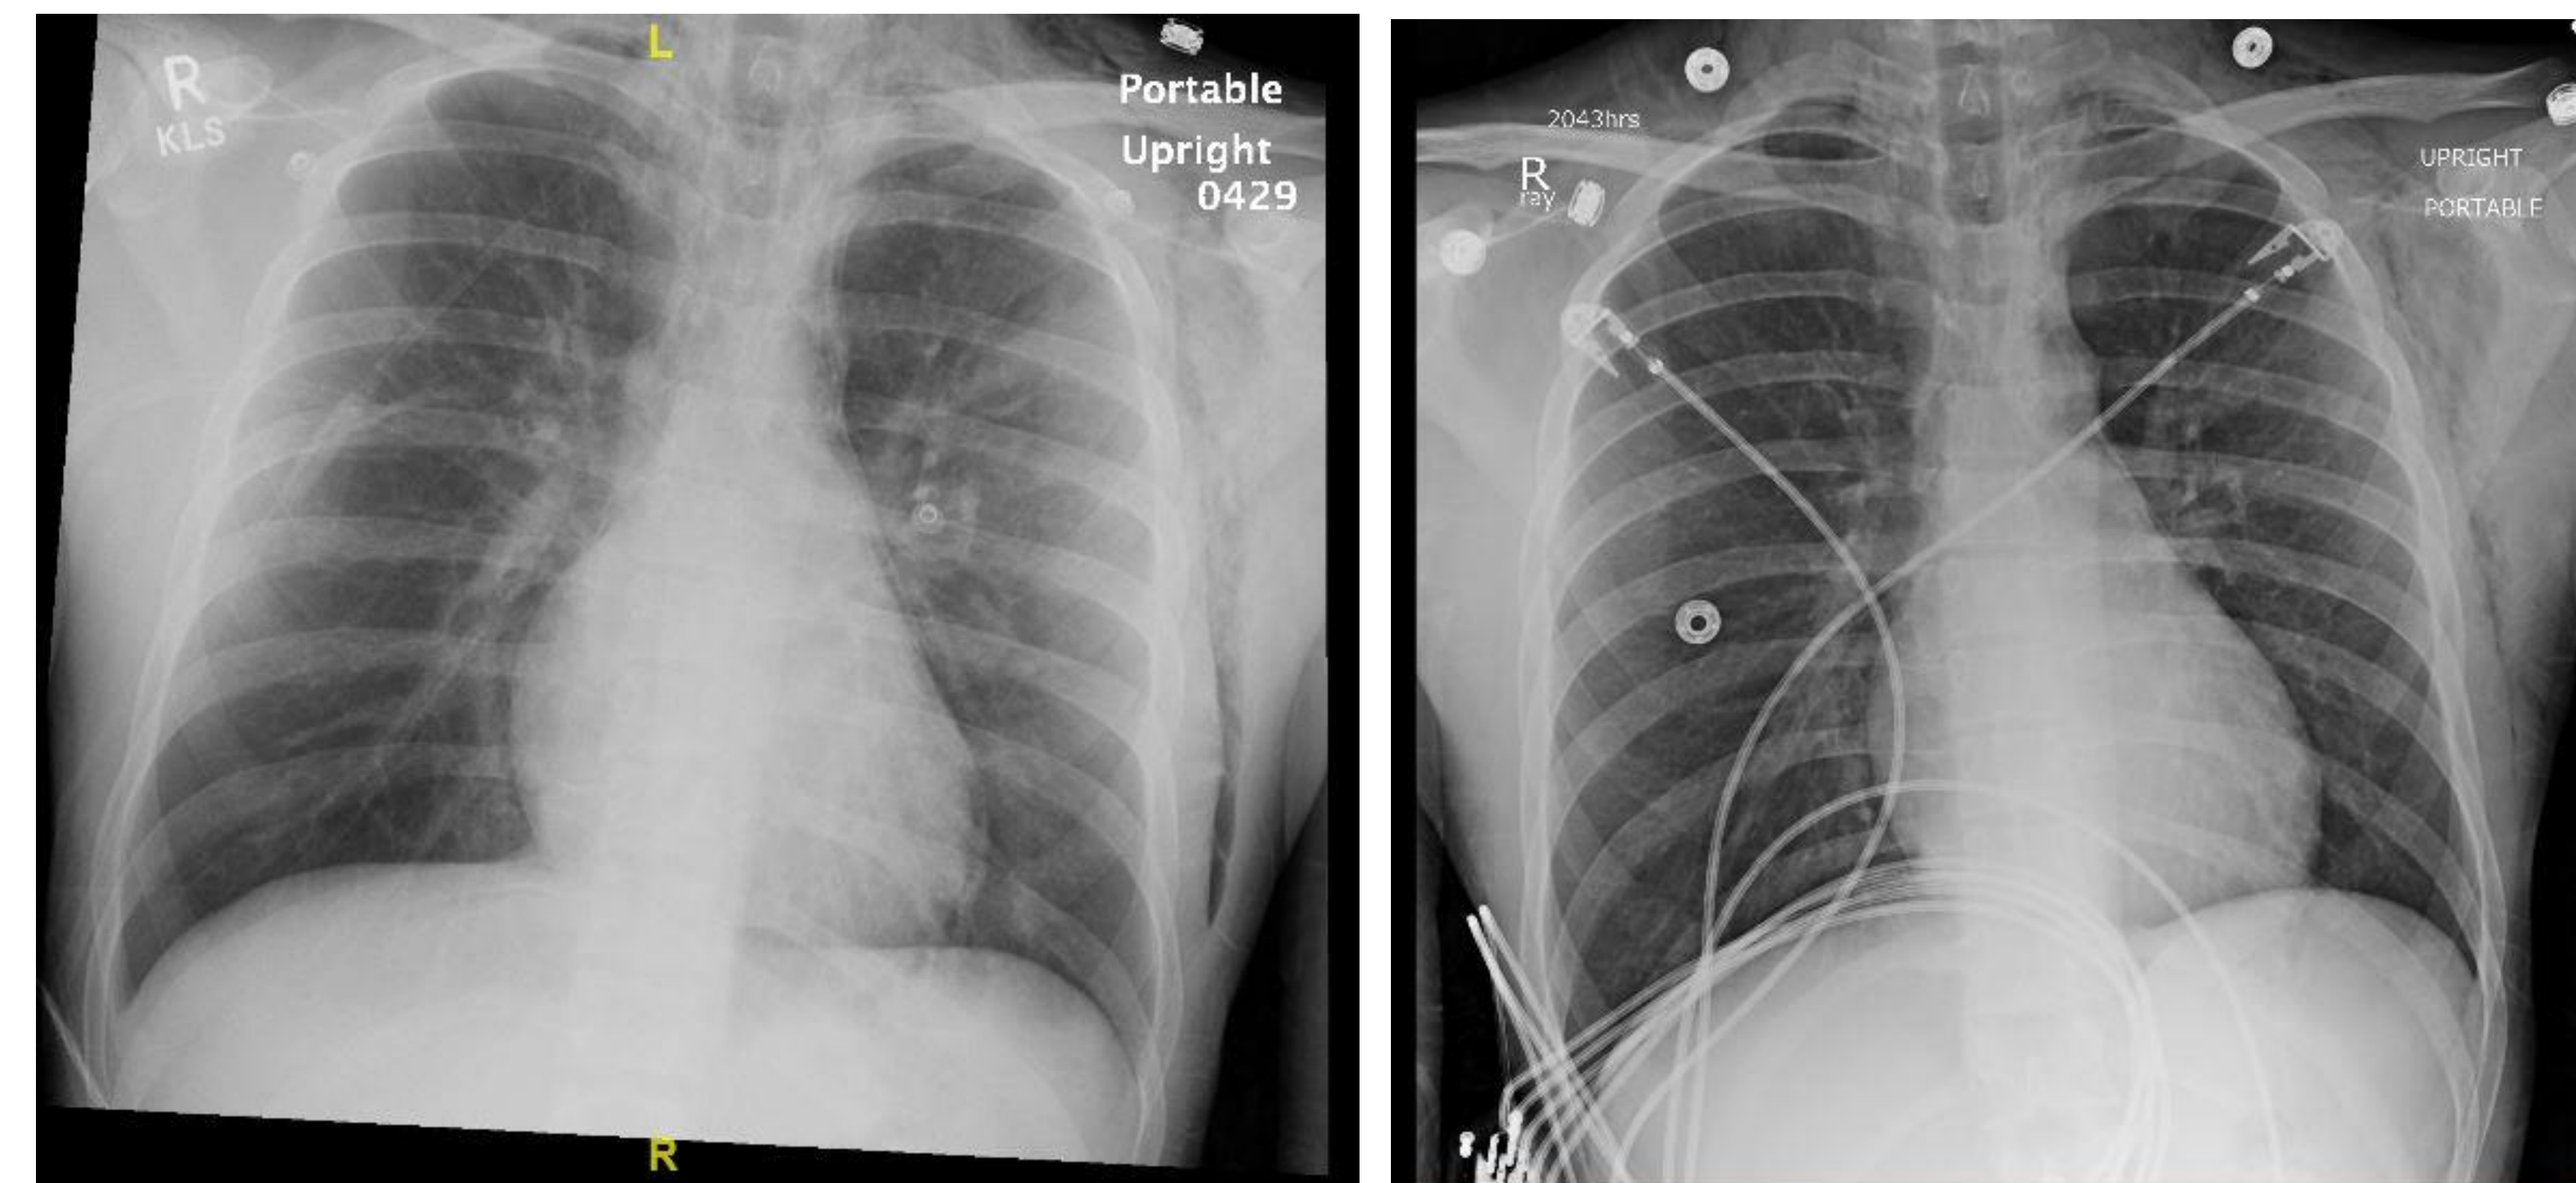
Initial chest x-ray (left) showed extensive pneumomediastinum along with subcutaneous emphysema on the left anteriolateral chest wall. Image on right is the chest x-ray two days later with improvement of the pneumomediastinum
